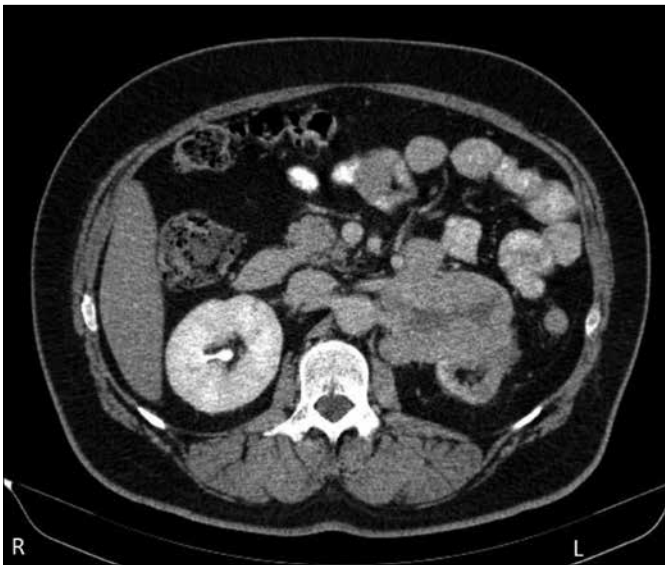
Computed tomography: transversal view of a 9-cm tumor in the upper pole of the left kidney.
